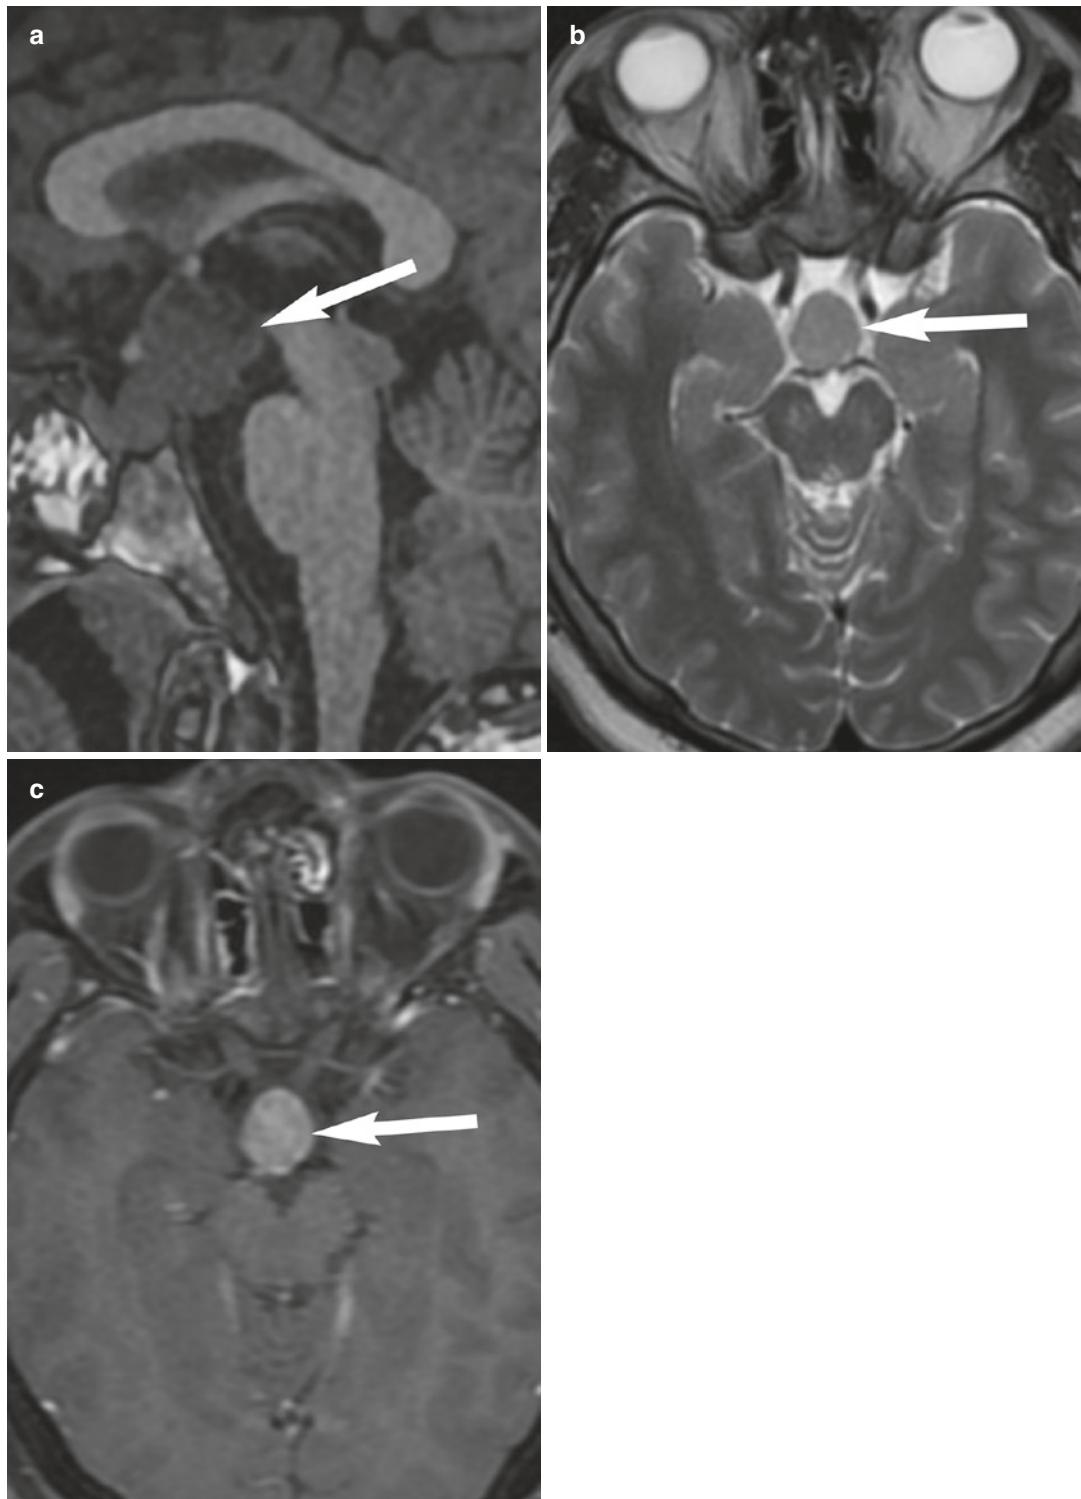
Germinoma*. A 15-year-old male with headache and diabetes insipidus. Sagittal (a) unenhanced T1-weighted and axial (b) unenhanced T2-weighted images show a circumscribed suprasellar mass causing infundibular thickening. It is isointense to gray matter on
